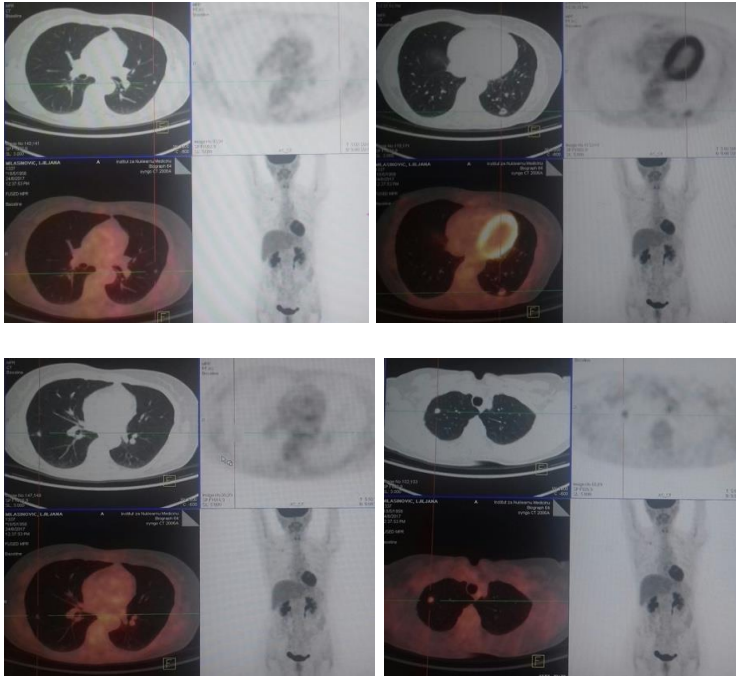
18F-FDG positron emission computed tomography scans in the axial and coronal planes after systemic chemotherapy, demonstrating four nodular lung lesions with an increased uptake of radiopharmaceutical
